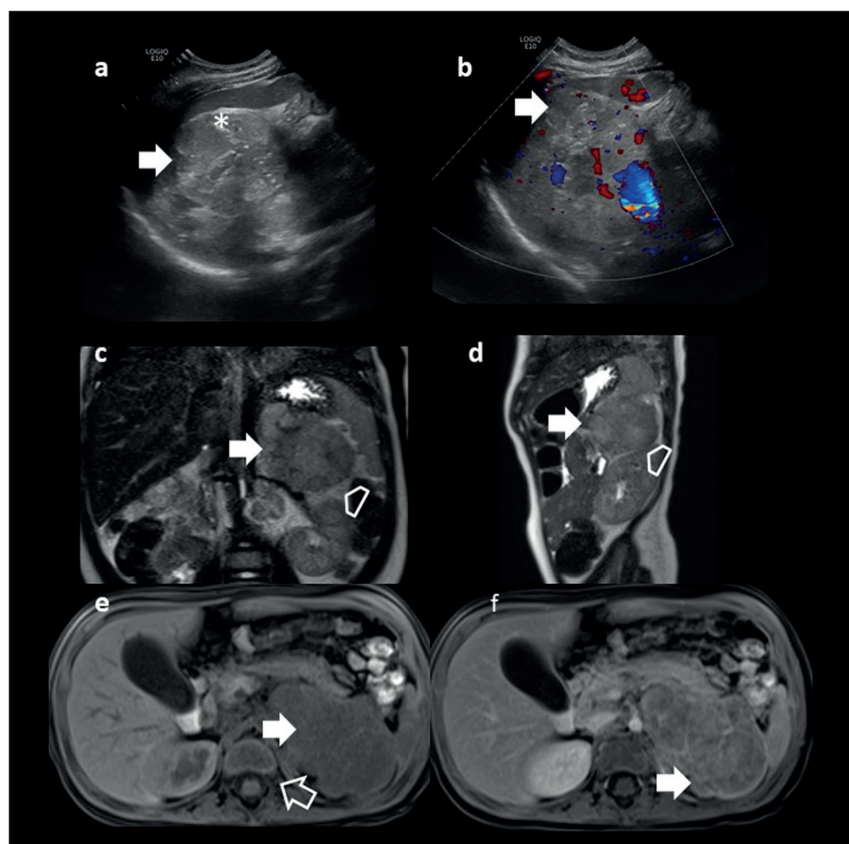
1a y 1b. Abdominal ultrasound showing a solid lesion located in the left adrenal region (solid arrow) that presents hyperechoic foci inside compatible with calcifications (asterisks) and vascular flow in the Doppler study. 1c, 1d, 1e, 1f. Magnetic resonance image in coronal (c) and sagittal (d) T2-weighted sequences, and axial (e and f) T1-weighted pre- and post-contrast sequences respectively; a solid lesion (solid arrow) is observed hyperintense with the muscle in T2-weighted sequences and hypointense in T1-weighted sequences with progressive enhancement after the use of paramagnetic contrast (unfilled arrow), without evidence of invasion of the neuroforamen and with a cleavage plane with the kidney (arrowhead). These images are compatible with a neuroblastoma.
